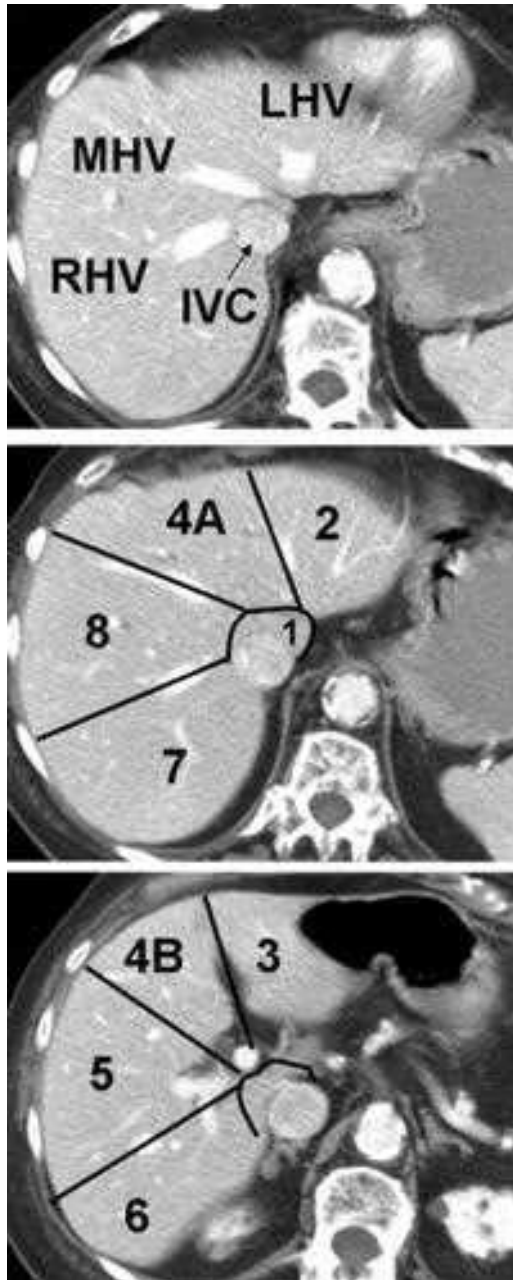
Computed tomographic (CT) images of hepatic veins and Couinaud's liver segments. The images show the three hepatic veins and inferior vena cava (IVC) (*upper panel*), as well as Couinaud's liver segments (*lower panels*). LHV = left hepatic vein; MHV = middle hepatic vein; RHV = right hepatic vein.
